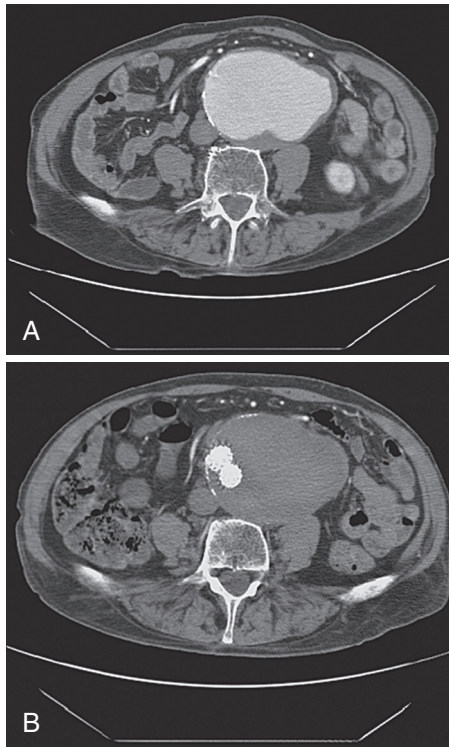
A, Cross sectional computed tomography (CT) image of an 11-cm abdominal aortic aneurysm. B, CT image 3 months after endovascular repair. Note the thrombosed aneurysm and patent limbs of the stent-graft. (From Townsend C, et al. Sabiston textbook of surgery. 18th ed. Philadelphia: Saunders, 2008, Fig. 65-4.)
